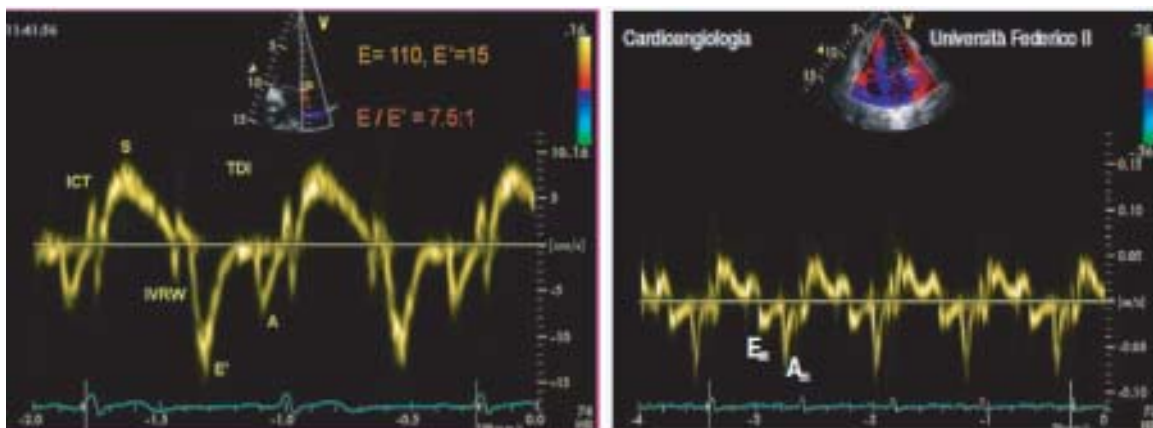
Normal tissue Doppler imaging (TDI) (left panel) and pattern of abnormal myocardial relaxation (right panel). The tissue Doppler recording at the lateral edge of the mitral annulus gave a peak E' of 15 cm/s, A_m = myocardial atrial velocity (cm/s), E_m (E_2) = myocardial early-diastolic velocity (cm/s).
